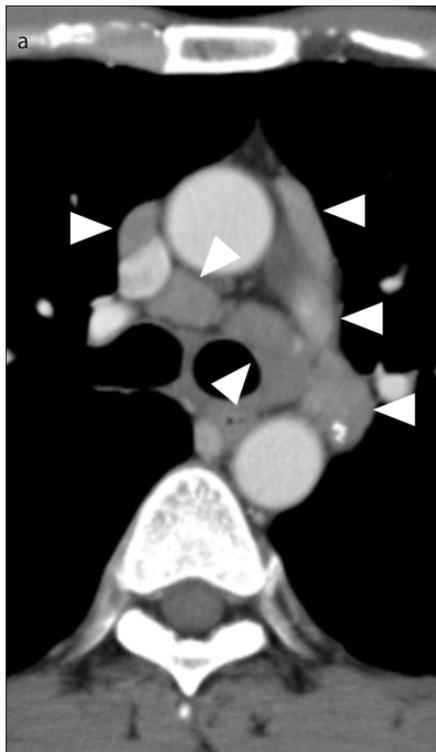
a, b. A 50-year-old man with acute ATL. A contrast-enhanced chest CT image reveals multiple mediastinal lymphadenopathies (a, arrowheads). Bronchiectasis, bronchial wall thickening, and multiple centrilobular opacities (ovoid circles) are observed in the left lung (b).
